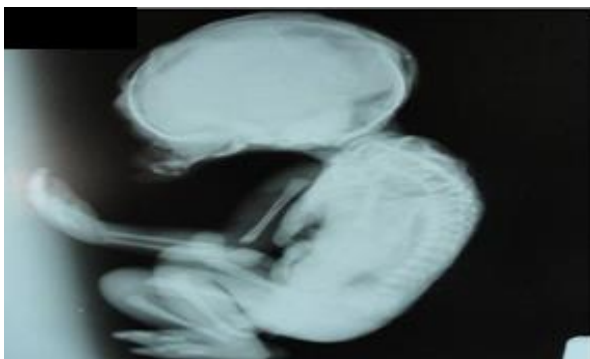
Radiograph showing small mandible and maxilla.
